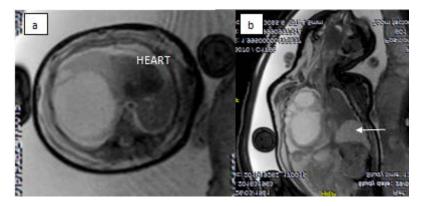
Fetal MRI performed at 36 weeks' gestation in axial (a) and coronal (b) section in SE T2: Right macrocystic lung mass (star) associated with a more marked pleural effusion on the left (arrow) and diffuse cutaneous infiltration (curved arrow).
